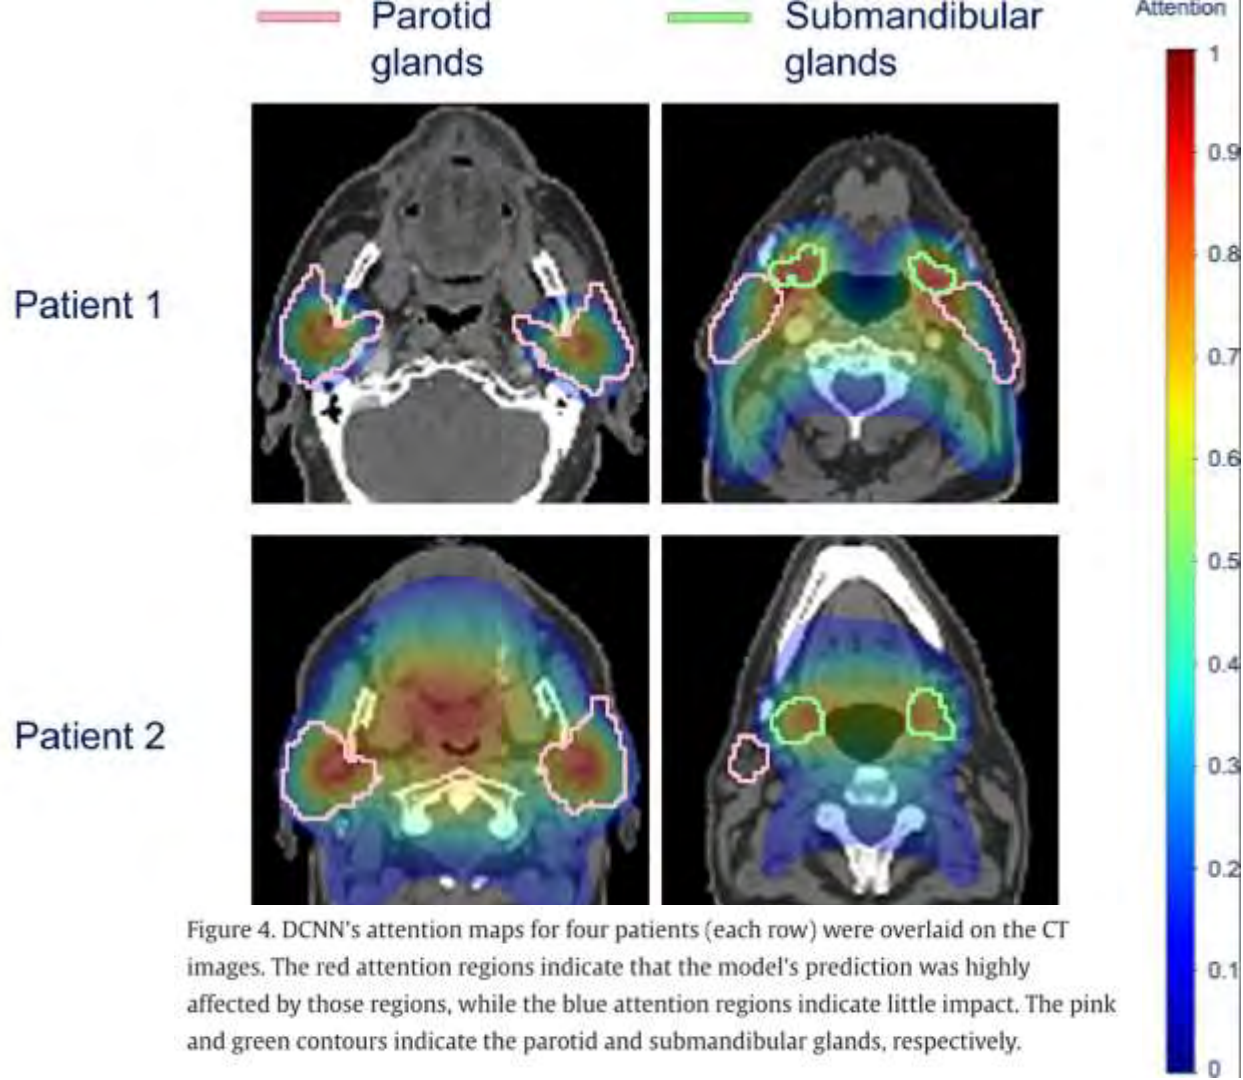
DCNN's attention maps for four patients (each row) were overlaid on the CT images. The red attention regions indicate that the model's prediction was highly affected by those regions, while the blue attention regions indicate little impact. The pink and green contours indicate the parotid and submandibular glands, respectively.
